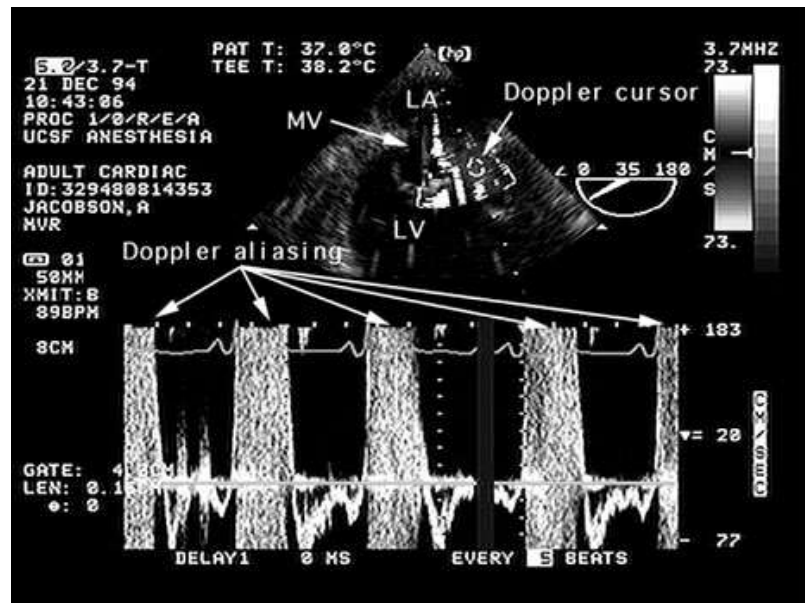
Pulsed-wave Doppler with aliasing at high velocities. Pulsed-wave Doppler measurement of blood flow velocities in a mitral valve (MV) orifice during four cardiac cycles is shown. At the top of the figure is a still-frame image of the two-dimensional cross section used to position the Doppler sample volume (the round white sphere). On the bottom two thirds of the figure is the display in white of the instantaneous blood flow velocities (vertical axis)
